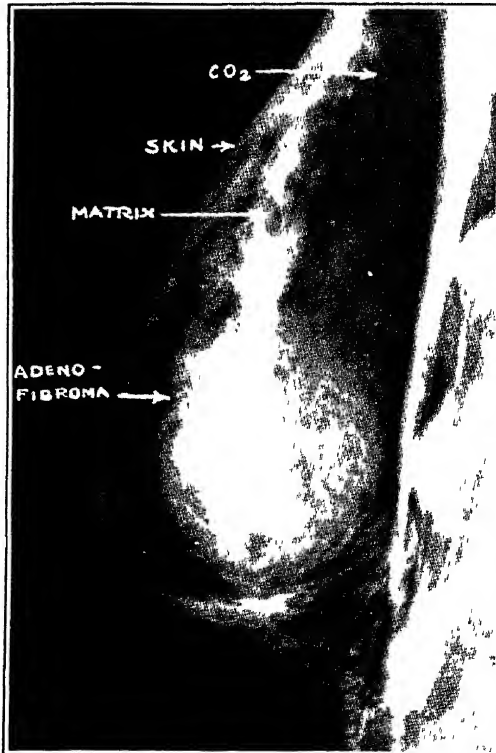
Fibroadenoma A firm, dense, encapsulated tumor can be seen arising from the matrix following CO₂ insufflations (Am J Roentgenol, March, 1938)
